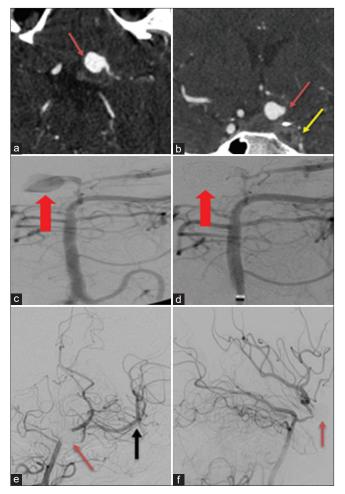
A 19-year-old female with the left cranial nerve VI palsy, CTA axial image (a) demonstrates saccular aneurysm from communicating segment of the left ICA (red arrow). Coronal plane (b) shows small lobulated extension anterolaterally (red arrow) and thrombosed left ICA with no contrast opacification (yellow arrow) compared to the contra lateral side which is normally opacified (not labeled). Cerebral angiogram right vertebral injection preembolization (c) demonstrates a 10 mm irregular lobulated aneurysm (red arrow) extending from the dysplastic communicating segment of left ICA. Post coil embolization (d), there is complete occlusion of the aneurysm (red arrow). One-month follow-up cerebral angiogram right vertebral injection anterior-posterior projection (e and f) shows the coil pack to be stable (red arrow) with complete occlusion and no evidence of recurrence. Persistent antegrade flow in the left middle cerebral artery (black arrow).
